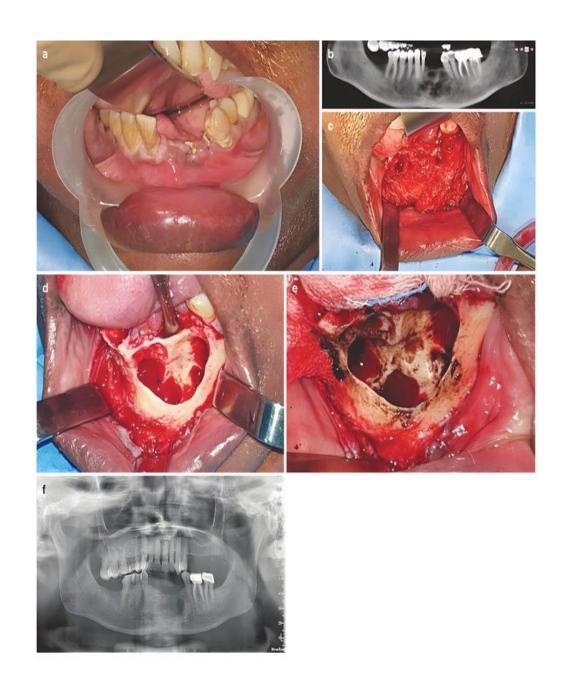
11(a) loosening of teeth and expansion of the gams in the anterior lower mandible . (b) A OPG and CBCT showing multilocular radiolu cency in the anterior mandible . (e) Lesion exposed (d) lesion excised and peripheral ostectomy done (e) carnoys solution applied to surgical bed . (f sixteen month post operative OPG (Anjan K. M. , 2021)
